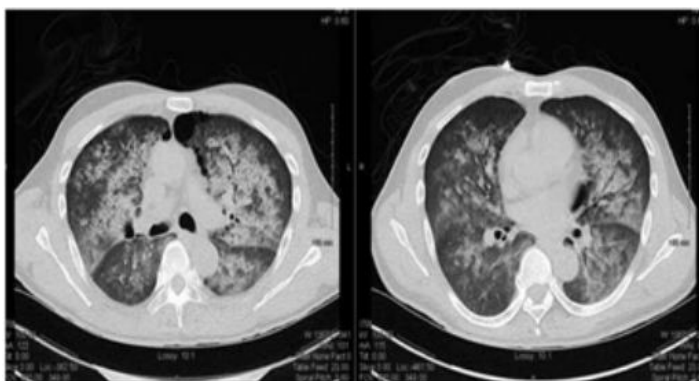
Chest CT from Outside Hospital Two Months Prior to Admission with Bilateral Airspace Consolidations and Ground Glass Opacities.
